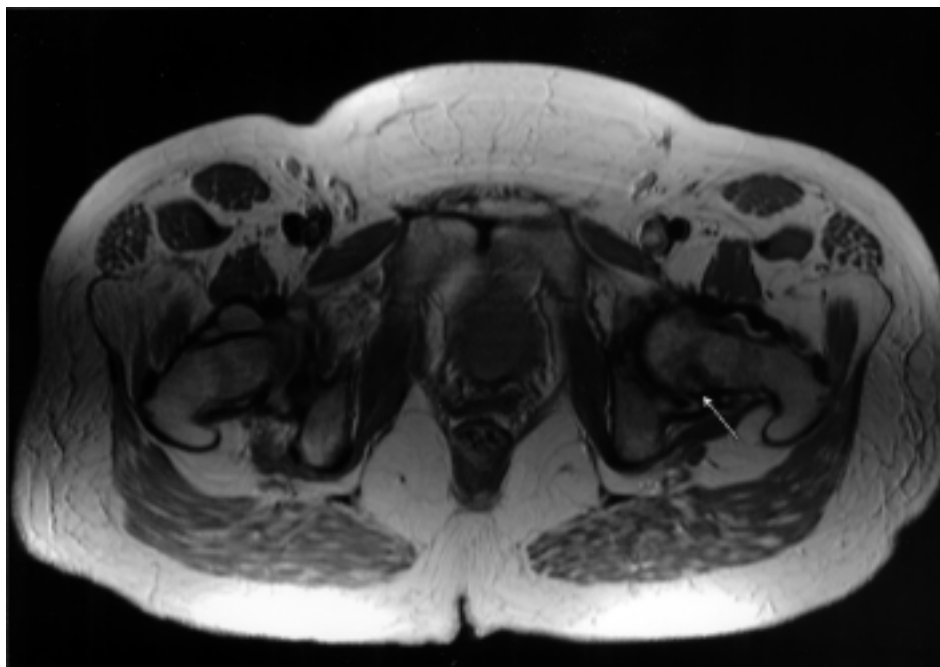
MRI of the left hip. A transverse proton-density image shows an area of decreased signal intensity in the posterior aspect of the left femoral neck (arrow). This position corresponds with the increased area of signal intensity on the STIR image.
